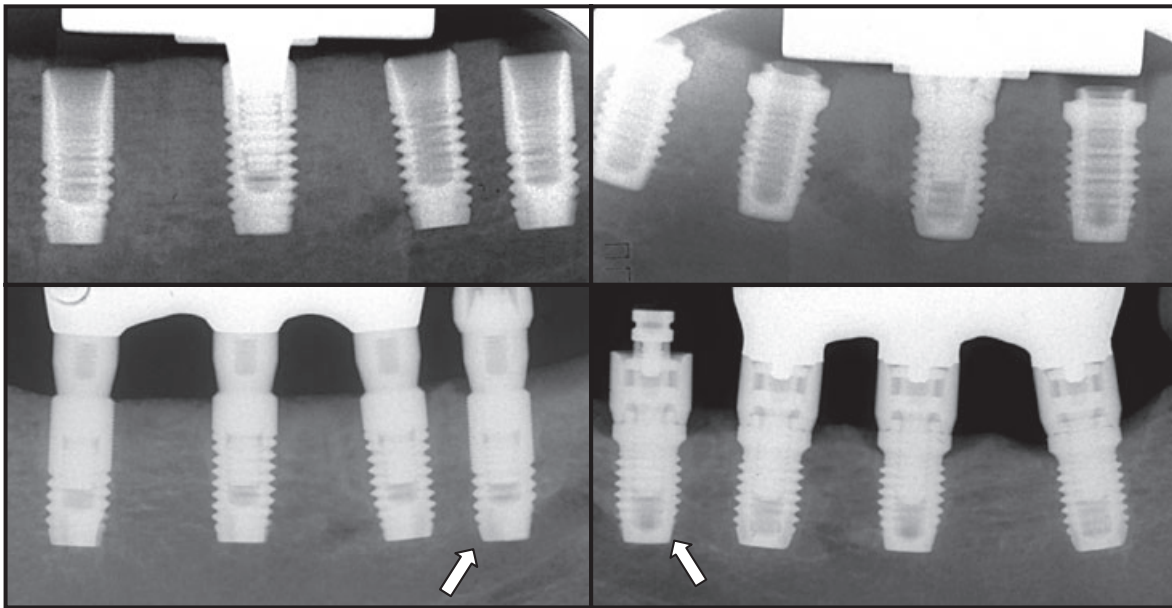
Radiographs obtained from Astra Tech® (left side) and Brånemark® (right side) implants immediately after implant installation (top row) and following 10 months of functional loading (bottom row). Unloaded control implants are indicated with arrows. From Berglundh *et al.* (2005).
